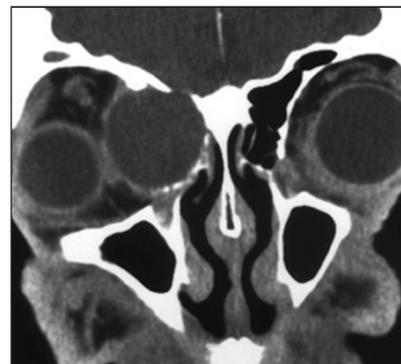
Computed tomography scan showing a smooth, homogenous, expansive mass eroding into the frontal sinus and orbit and displacing the globe laterally.
